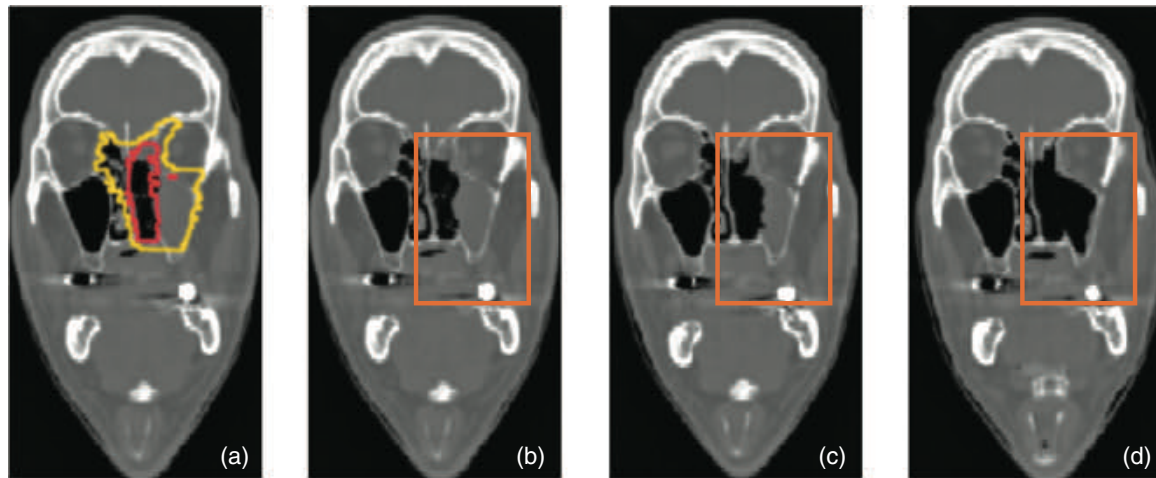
(a) Slice of the planning CT of the SCC patient with the CTV-low in yellow and the CTV-high in red. (b) Same, but now without target structures and with the region of interest, indicated as orange rectangle, containing the sinonasal cavity. (c) Corresponding slice of the first control CT. The sinonasal cavity is somewhat emptied, as can be seen by inspecting the region inside the orange rectangle. (d) Corresponding slice of the second control CT, where further emptying of the sinonasal cavity is visible
